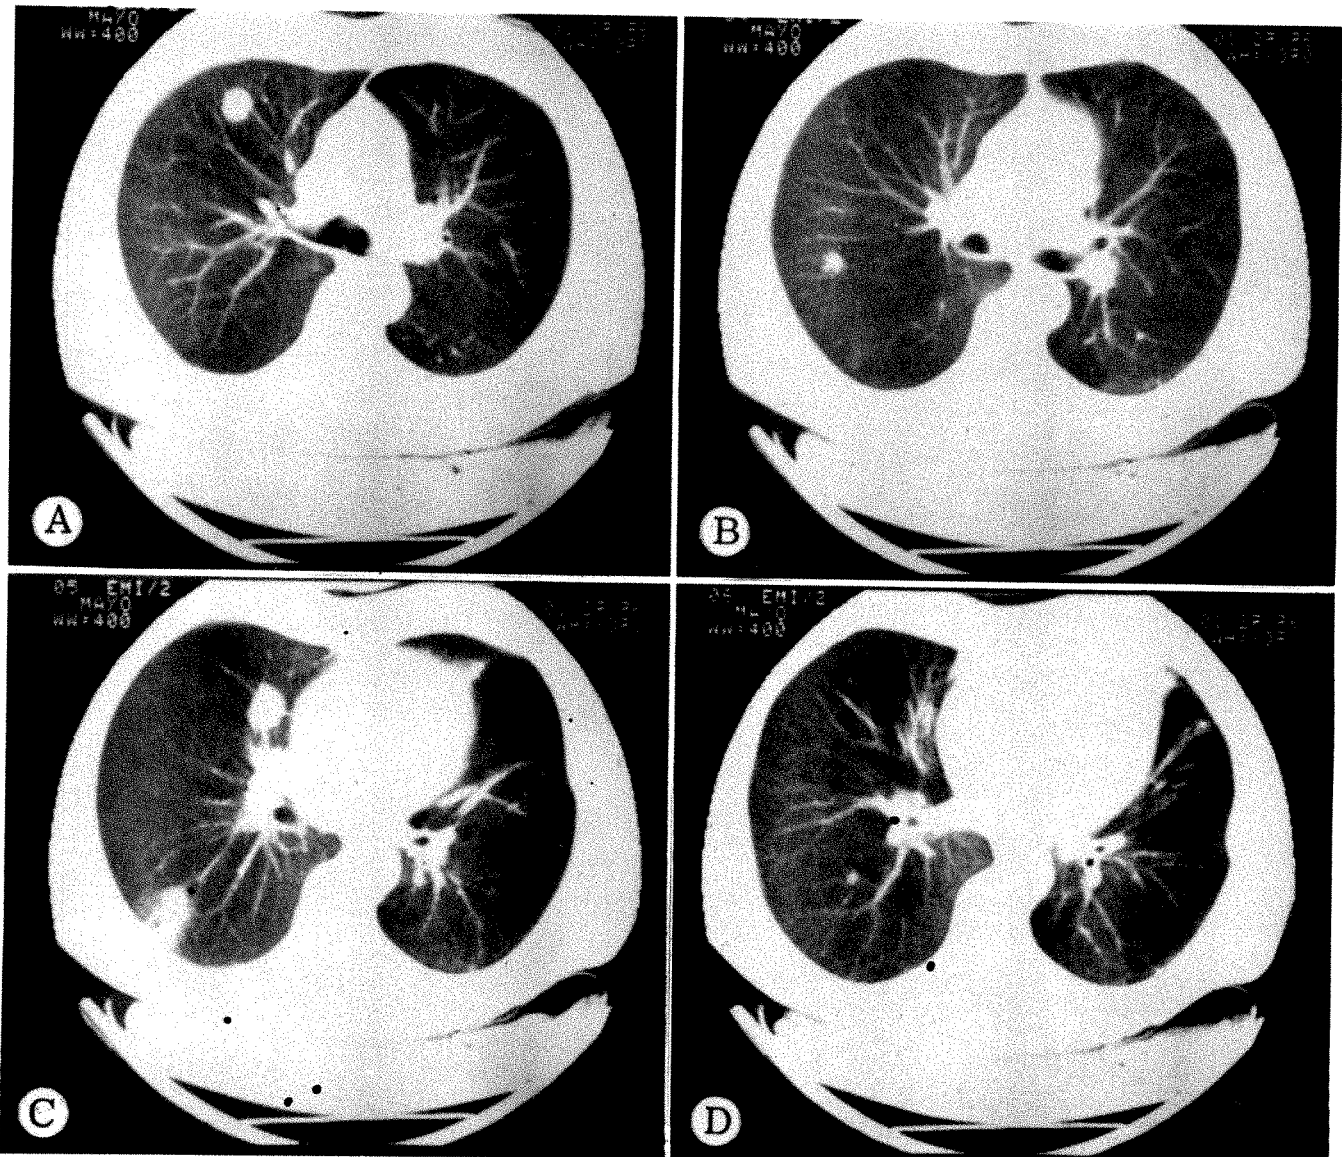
CT scans of 60-year-old man with two (possibly three) lung nodules on routine chest film and no known primary tumor. *A–D*, Multiple tomographic sections through lungs revealing multiple pulmonary nodules, some not seen on chest film. Biopsy showed nodules (1–3 cm) to be grades 2 and 3 metastatic adenocarcinoma (still of unknown primary origin).
